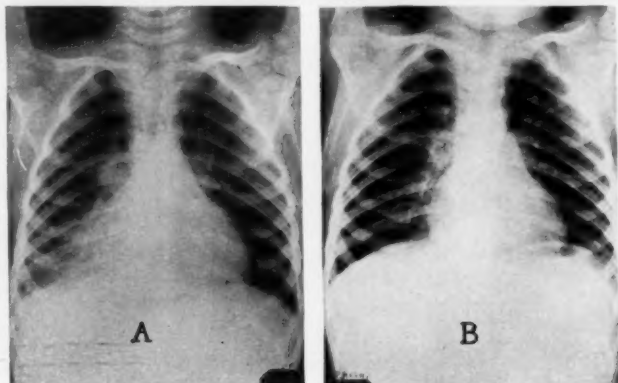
Case 2. (A) Atelectasis of the right lower lobe following the aspiration of a "Root Beer Drop." (B) Chest X-ray following bronchoscopic aspiration.
